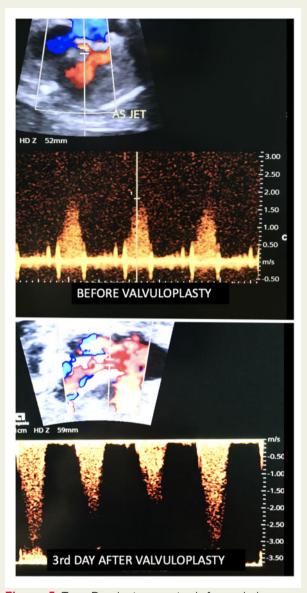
Top—Doppler interrogation before and—bottom on the third day after foetoscopy-assisted foetal balloon valvuloplasty shows an increase of the flow velocity across the aortic valve from \sim 1.75 m/s before to more than 3 m/s after the intervention.
